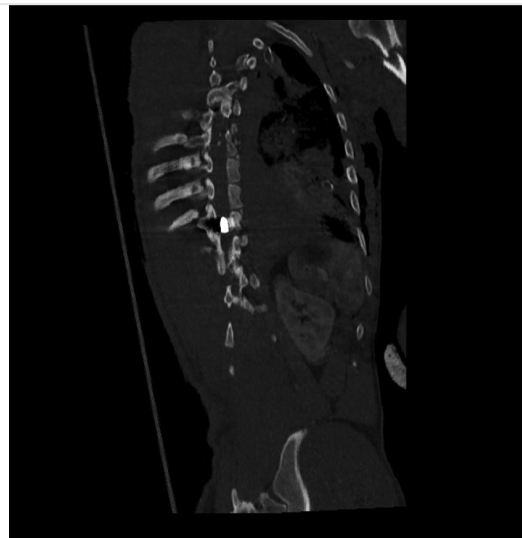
Sagittal computed tomography scan demonstrates the entrance of the bullet from the left inferolateral border of T7 vertebral body (white arrow) and intracanalicular bone fragments
